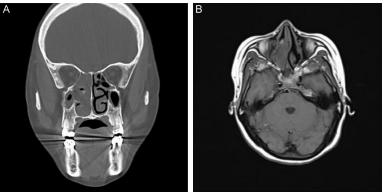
A: Coronal computed tomography (CT) of the Paranasal Sinuses. Soft tissue density shadow in the right nasal cavity and paranasal sinuses, with enlargement and obstruction of the nasal sinus ostium complex. B: Axial CT of the paranasal sinuses shows soft tissue density shadows in the right nasal cavity and nasopharynx, which blocks the airway. No obvious abnormalities are observed in the bony structures of the sinus walls.
